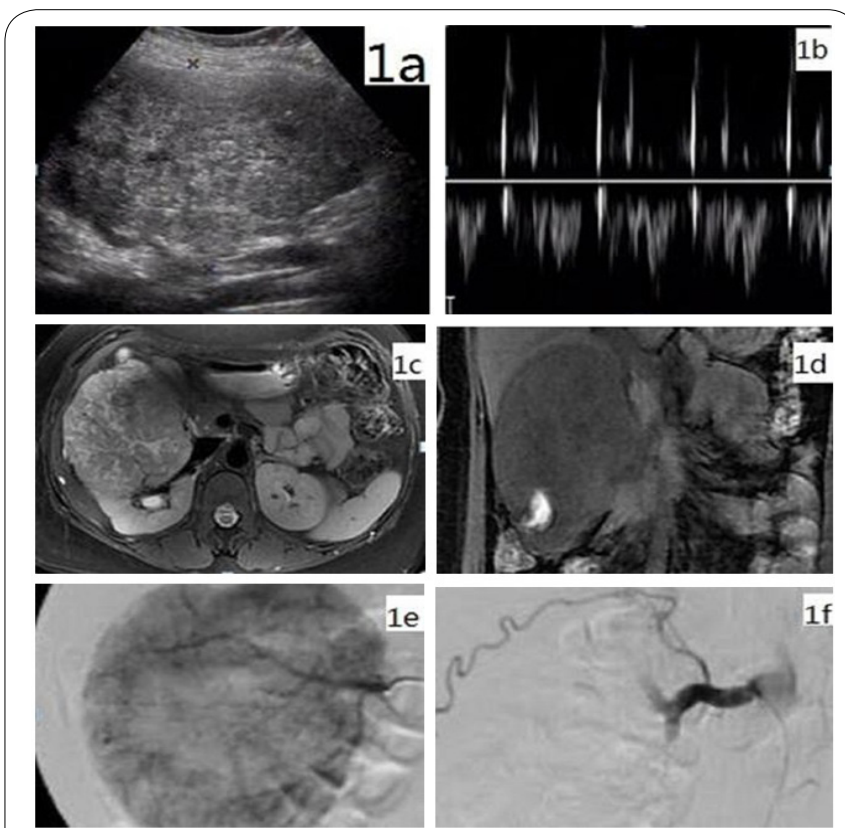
Right renal cell carcinoma in a patient who underwent RAE followed by nephrectomy. A 36-year-old woman with a 11×7 cm right renal cell carcinoma underwent preoperative right renal artery embolization followed by uneventful right nephrectomy with a total estimated blood loss of 200 mL. A, B: Ultrasound image showing a huge occupying lesion in the right kidney, presenting a mixed echo and moderate blood flow. C, D: Axial and coronal T2WI MRI images of the right renal mass with mixed signal. E: Selective right renal arteriogram demonstrating a large hypervascular renal cell carcinoma before embolization. F: Post-embolization selective right renal arteriogram demonstrating near-complete embolization of the right renal artery to stasis.
